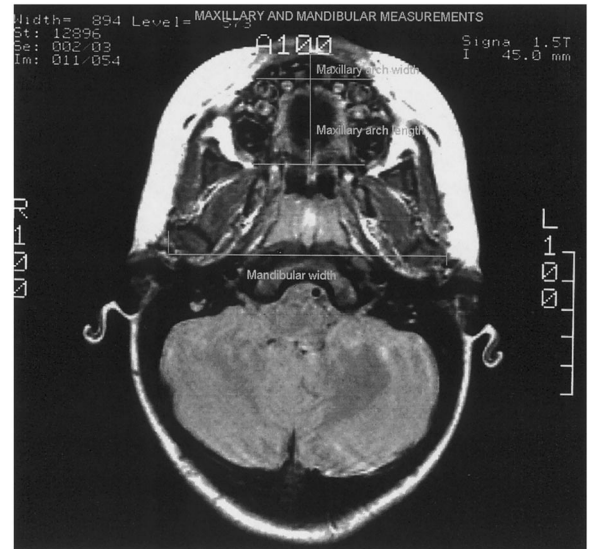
Maxillary and mandibular measurements from an axial MRI slice of a 2-year-old male subject.
